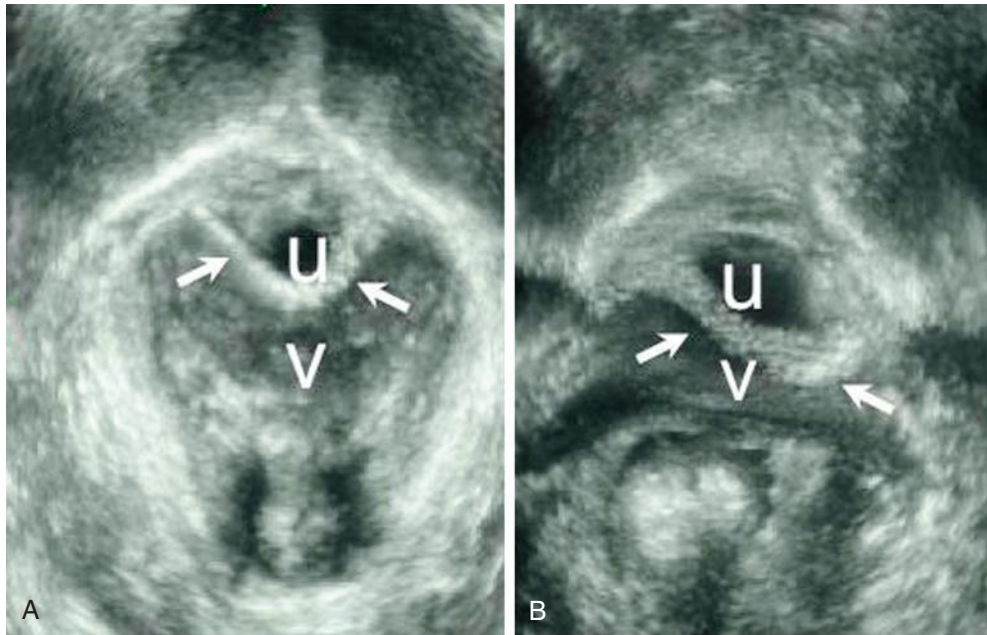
Axial (transverse) images of two types of midurethral synthetic mesh slings (*arrows*). A, A retropubic sling. B, A transobturator sling (Monarch) sling. The synthetic mesh is woven and this woven mesh-like quality is easily captured by ultrasound imaging as a highly echogenic structure. The normal anatomic landmarks are annotated on the images: u, urethra; v, vagina.
